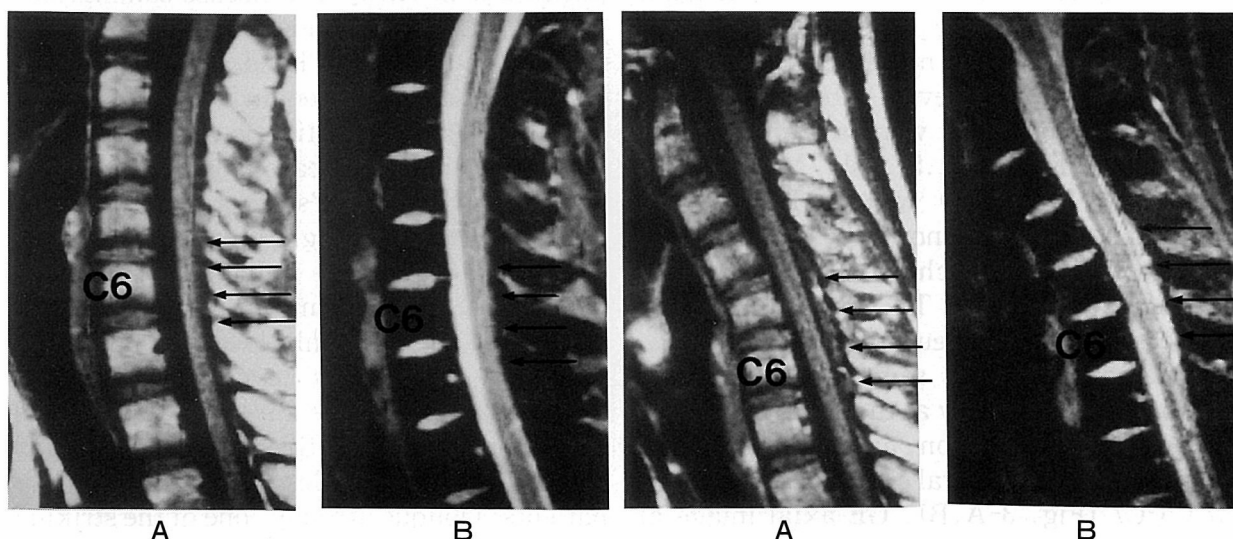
(A) T1-weighted sagittal spin-echo (SE) image. (B) Gradient-echo (GE) sagittal image. In the neutral neck position, localized cord atrophy at the C5-7 level is seen (arrows).
